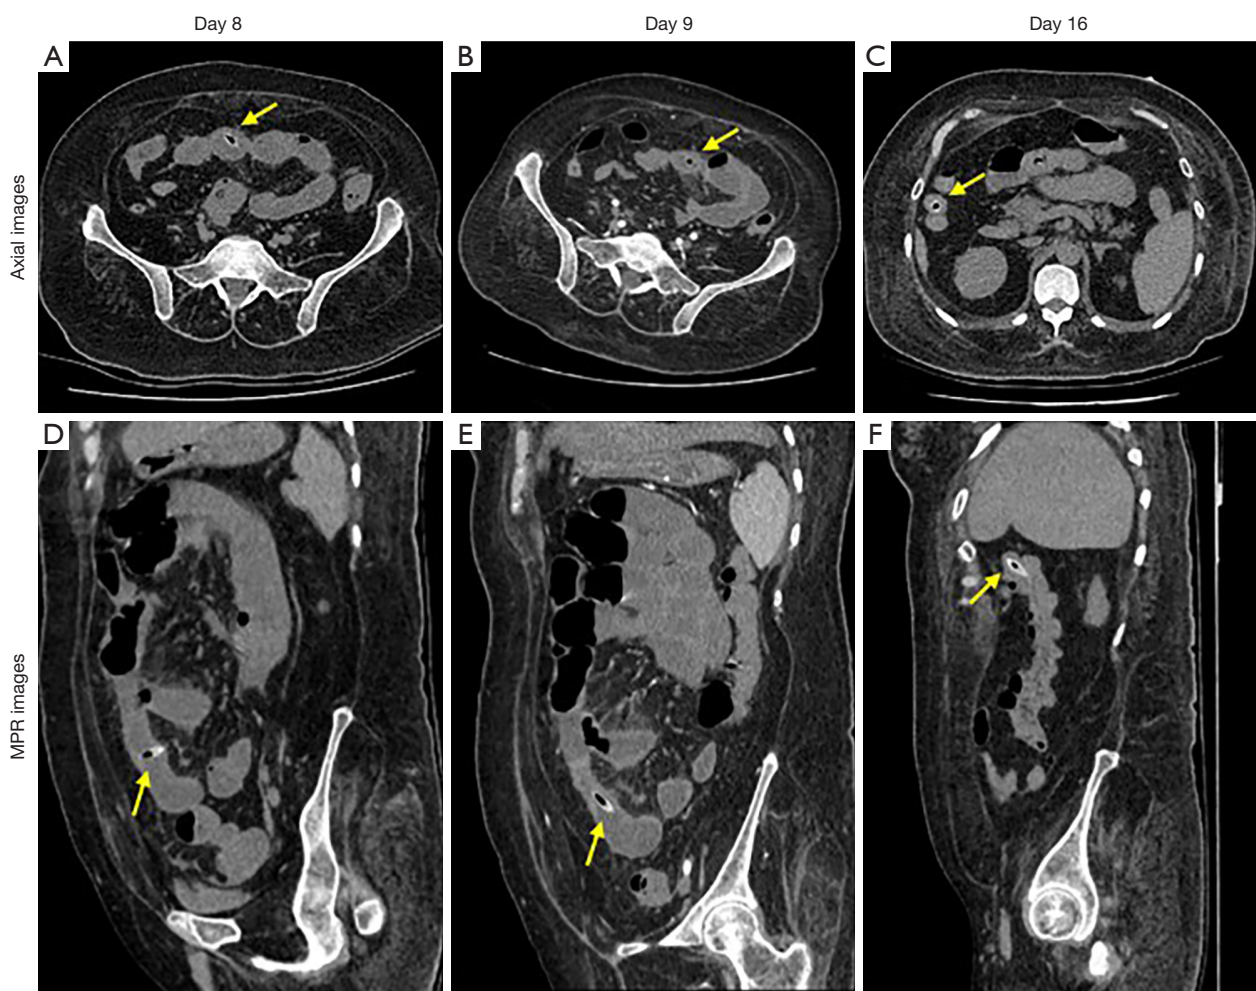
CT monitoring intestinal perforation caused by a jujube pit. A 51-year-old woman presented with complaints of abdominal pain for one week without a history of jujube pit ingestion. Abdominal examination revealed abdominal tenderness and rebound tenderness. CT revealed a jujube pit foreign body penetrating the intestinal wall, causing intestinal perforation. The patient was given conservative treatment because of contraindications, such as cardiac insufficiency and diabetes. The jujube pit passed with the stool at last. CT follow-up images on the 8th (A, D), 9th (B, E), 16th (C, F) day dynamically show the whole process of jujube pit (yellow arrows) leaving the perforation site and moving downstream spontaneously. (A-C) Jujube pit appears as a small, high-density ring on transverse images; (D-F) MPR images revealed jujube pit as a typical shuttle shape and clearly showed the relationship between jujube pit and the intestinal wall. MPR, multiplanar reconstructions; CT, computed tomography.
